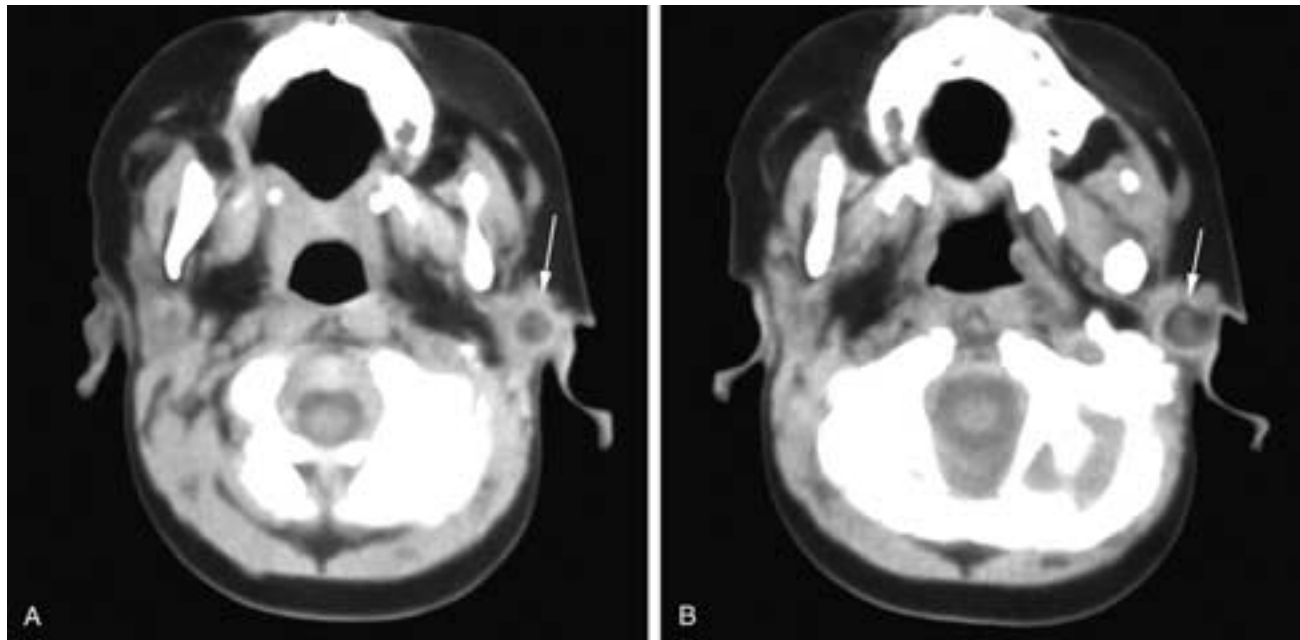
Axial CT scans just caudal to the skull base (A) and at the skull base (B). In A, there is a cyst (arrow) in the immediate infra-auricular region on the left side of this young child. In B, there is extension of the cyst into the left external auditory canal, which is widened by pressure from the cyst (arrow). This was a type I first branchial cleft cyst. Axial contrast enhanced CT scans cranial (C) to caudal (D). There is a cyst in (C) overlying the right parotid gland with enhancing inflammation surrounding it. This inflammation extends up to the right pinna (D). This patient had a type II first branchial cyst.
